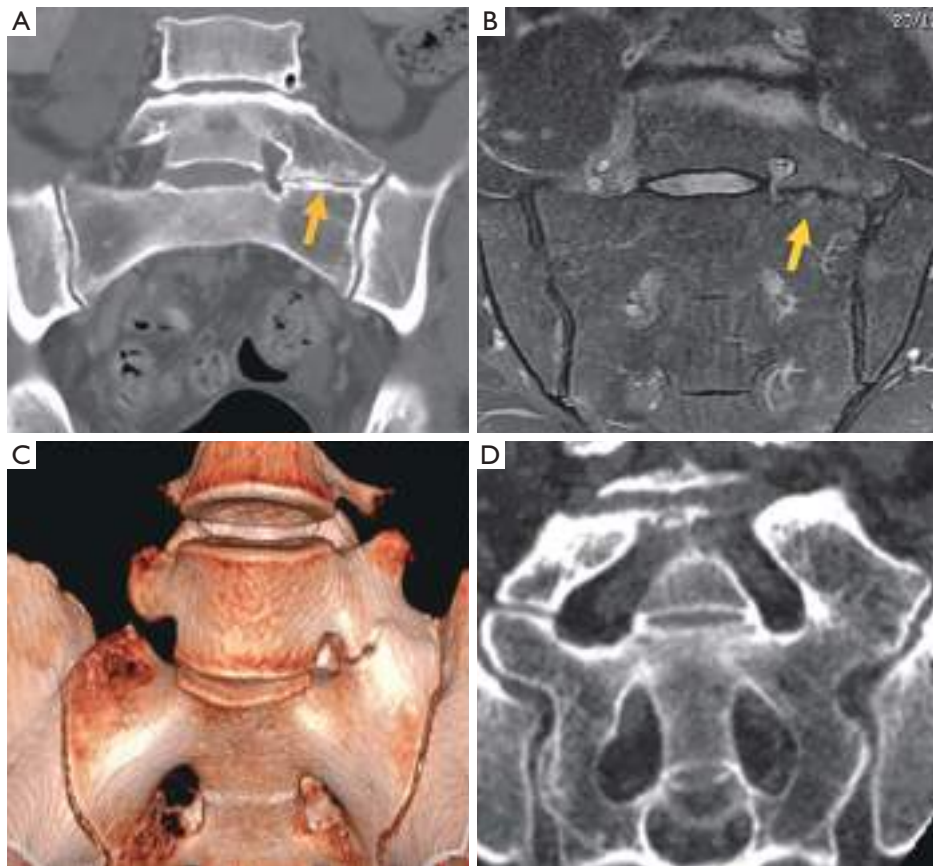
Castellvi types of transitional vertebra in three cases. Type II on CT depicting the neo articulation (arrow) (A) and MRI (B) showing the subchondral edema (arrow). (C) Type III on 3D CT. (D) Type IV on coronal CT. CT, computed tomography; MRI, magnetic resonance imaging.
